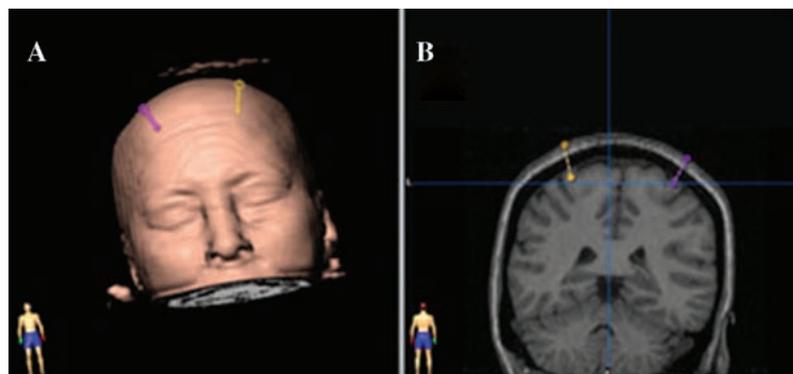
MRI neuronavigation brain 3D model. (A) Amyotrophic lateral sclerosis (ALS) subject and (B) MRI coronal posterior view showing frontal motor strips location bilaterally.
